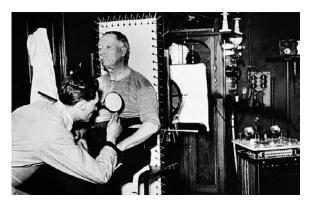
A seated man is attached to equipment by a technician to have an X-ray taken. Photograph c. 1925. Wellcome Library, London.
